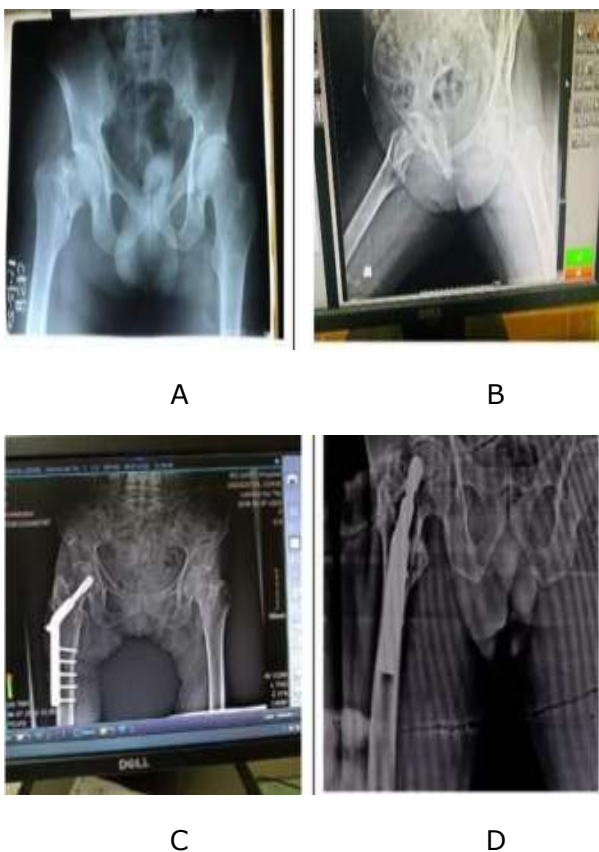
A, B, C, D Pre op and post op x-ray of DHS patient
